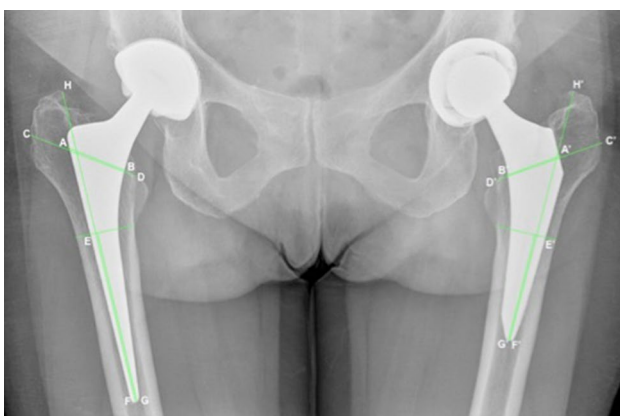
X-ray, anterior–posterior view of the pelvis. Measurements of bone invasivity in metaphyseal region and femoral shaft with GTS and CLS stem. The invasion of the metaphyseal region is expressed in percentage with the ratio AB/CD in CLS stem and $A'B'/C'D'$ in GTS stem. The invasion of the femoral shaft is expressed in percentage with the ratio EF/GH in CLS stem and $E'F'/G'H'$ in GTS stem
